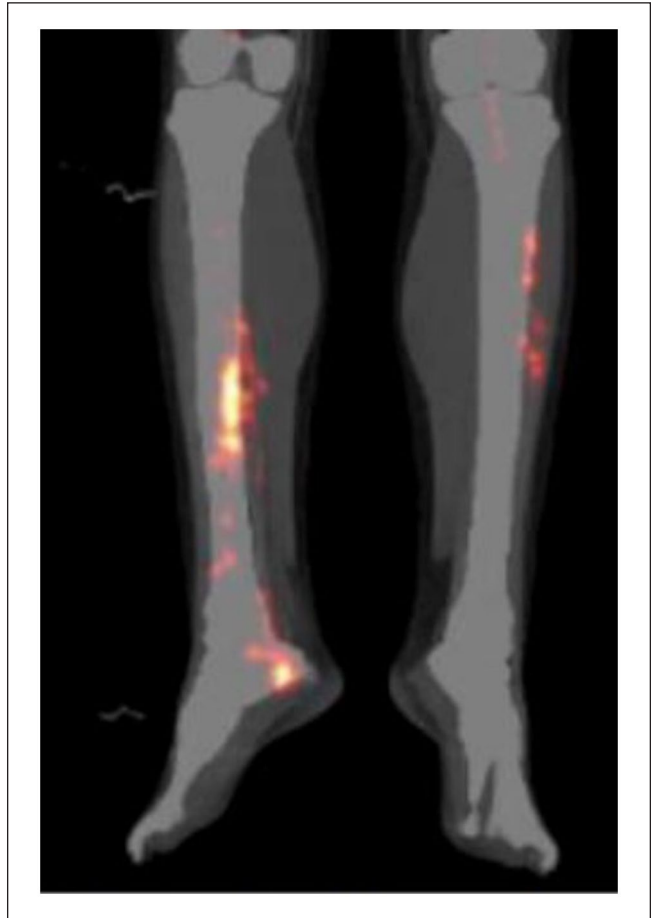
Multifocal segmental activity related to the lower limb arteries representing active vasculitis on F-18 FDG PET/CT of the body.
